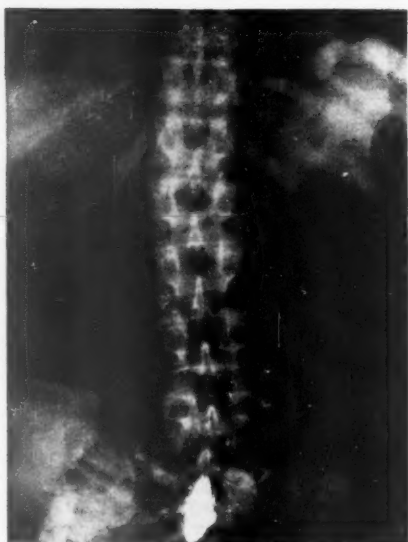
Plain film after partial gastrectomy showing a single distended loop of small bowel. The erect film showed no evidence of fluid level.
